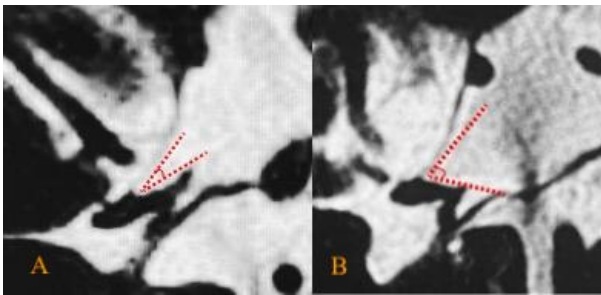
Mid sagittal MRI T2 shows variation in OC-LT angle ranging from 30 degrees in A to 60 degrees in B.
